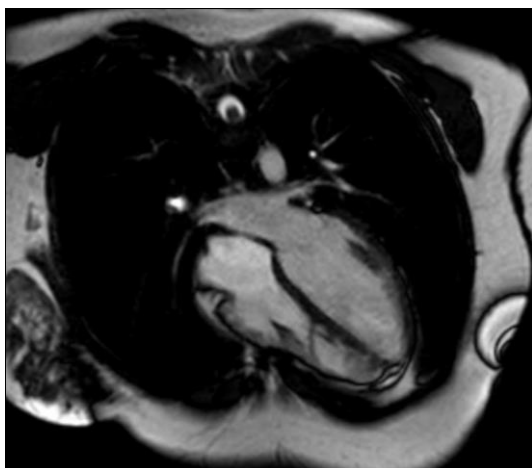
The patient's Cardiac MRI, showing features of ARVD
